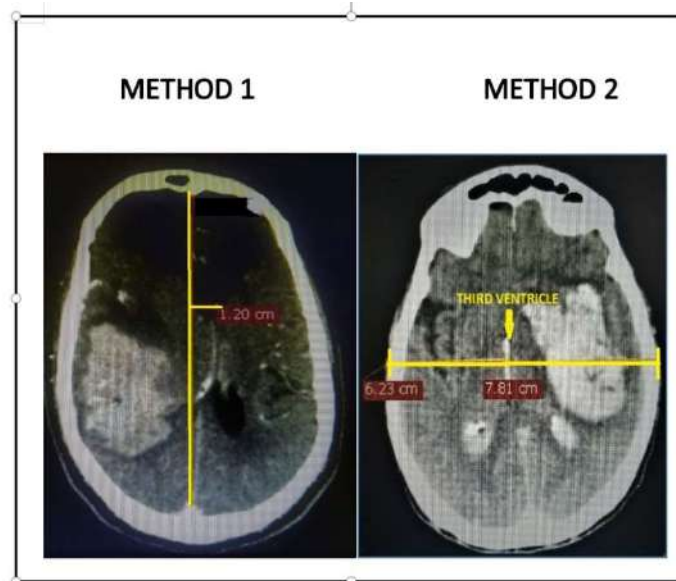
CT scan methods of measuring MLS. (Method-1: Distance between the midline and the septum pellucidum, Method-2: Determining midline from third ventricle).
